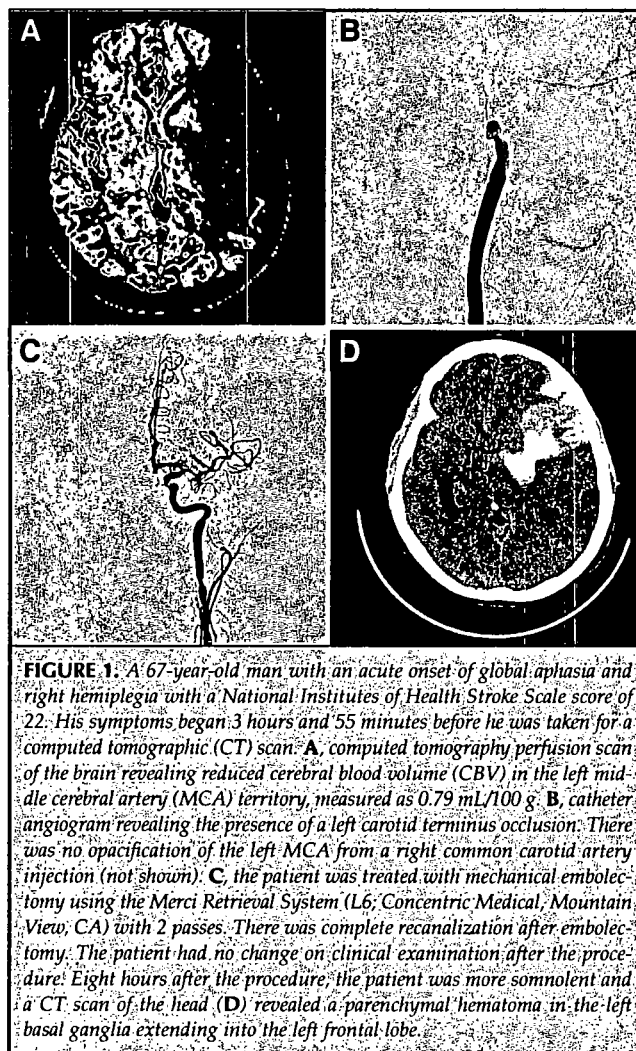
A 67-year-old man with an acute onset of global aphasia and right hemiplegia with a National Institutes of Health Stroke Scale score of 22. His symptoms began 3 hours and 55 minutes before he was taken for a computed tomographic (CT) scan. A, computed tomography perfusion scan of the brain revealing reduced cerebral blood volume (CBV) in the left middle cerebral artery (MCA) territory, measured as 0.79 mL/100 g. B, catheter angiogram revealing the presence of a left carotid terminus occlusion. There was no opacification of the left MCA from a right common carotid artery injection (not shown). C, the patient was treated with mechanical thrombectomy using the Merci Retrieval System (L6; Concentric Medical, Mountain View, CA) with 2 passes. There was complete recanalization after thrombectomy. The patient had no change on clinical examination after the procedure. Eight hours after the procedure, the patient was more somnolent and a CT scan of the head (D) revealed a parenchymal hematoma in the left basal ganglia extending into the left frontal lobe.
